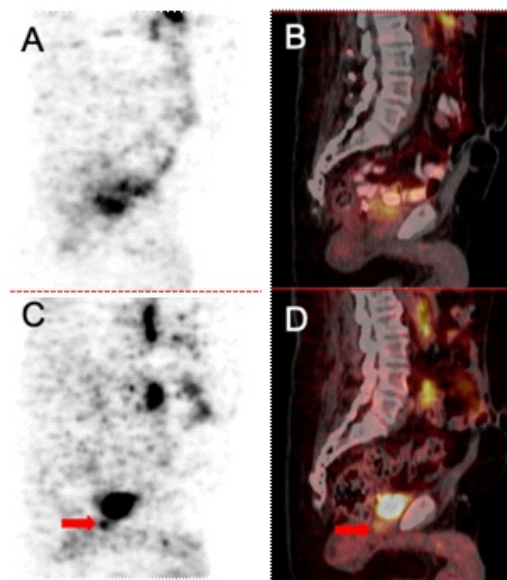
69 year old male, Gleason grade 5, with PSA of 8.12ng/ml. Sagittal ^{18}F -1007-PSMA PET (A) and fused (B) images demonstrating negative local recurrence. ^{68}Ga -PSMA-11 sagittal PET (C) and fused (D) images demonstrating uptake which was deemed positive for prostate uptake (arrow).
